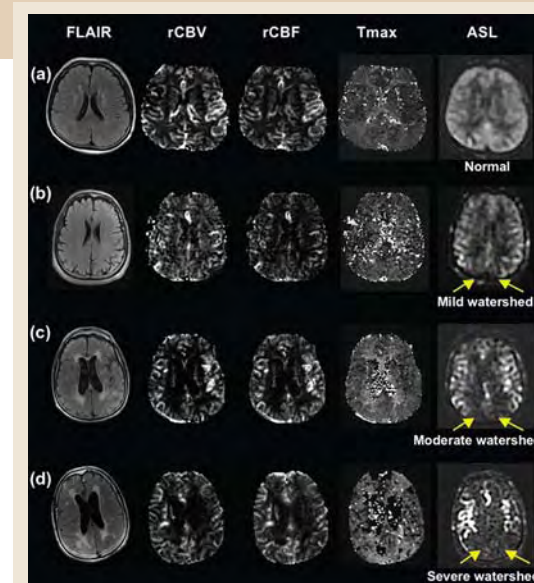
Common ASL imaging findings in patients with normal bolus perfusion-weighted imaging (PWI). Many ASL studies had signal dropout in the bilateral MCA-ACA and MCA-PCA borderzones with serpiginous high signal in the surrounding cortex, which we have termed a “watershed sign.” This ranged from mild to severe as shown above. In the severe case, only the proximal segments of the MCA and ACA are visualized with complete lack of parenchymal ASL signal. Fluid-attenuated inversion recovery (FLAIR) images as well as maps from bolus PWI (rCBV, rCBF, and Tmax) are shown for comparative purposes.
